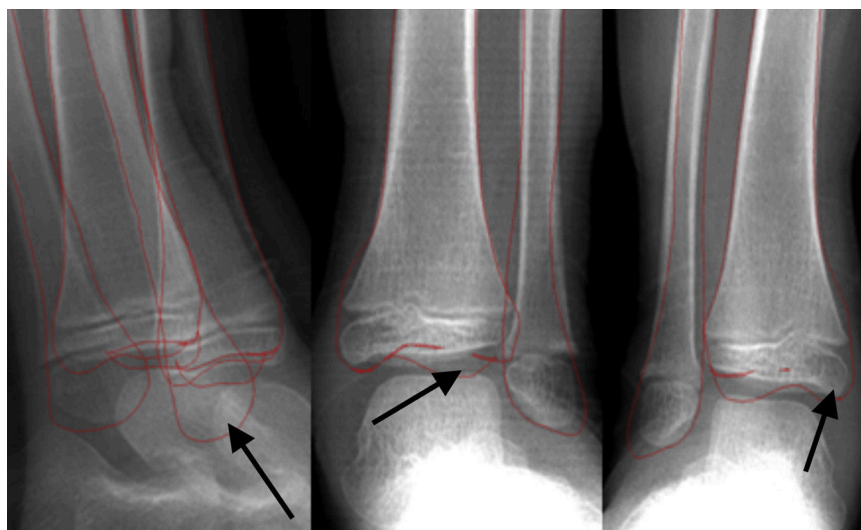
Ankle biplanar X-ray in a 6-year-old child. Black arrows show the zones with a poor definition due to incomplete ossification.
